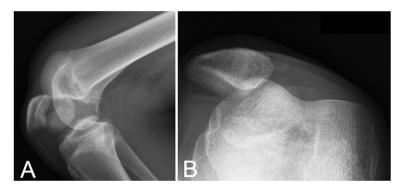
A) Lateral radiograph of the left knee showing patellar dislocation and condyle fracture of the distal femur. B) Axial radiograph of the dislocated patella and a osteochondral flake.
